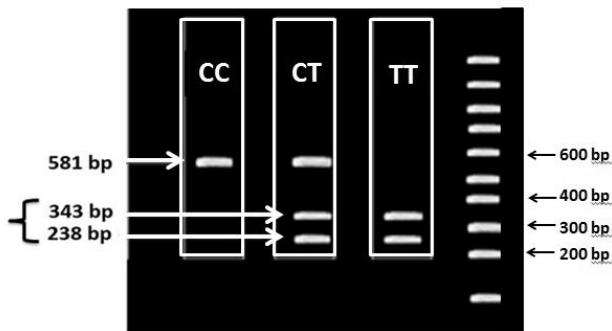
Representation of *Bgl* II digest of the amplified 581-bp PCR product. The first three lanes correspond to three patients with *ITGA2* 807 genotypes CC, CT and TT, respectively. The last lane corresponds to DNA ladder, used for comparison.
